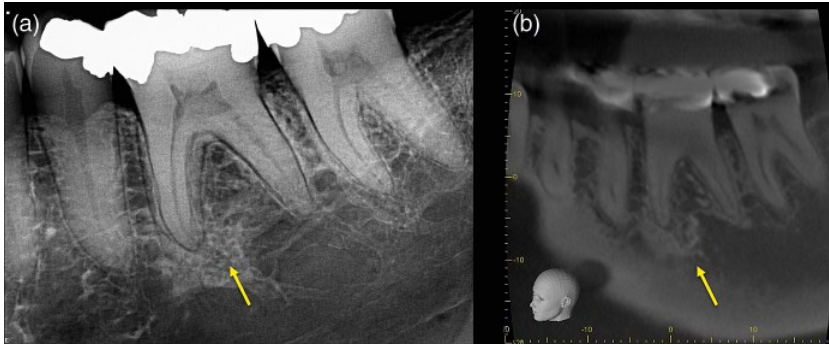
Condensing osteitis. (a) Periapical radiograph and (b) sagittal CBCT scan reveals increased radiopacity associated with the mesial root of the mandibular molar tooth, a sign of reactive osteosclerosis (yellow arrow) due to chronic irritation in the 46.
